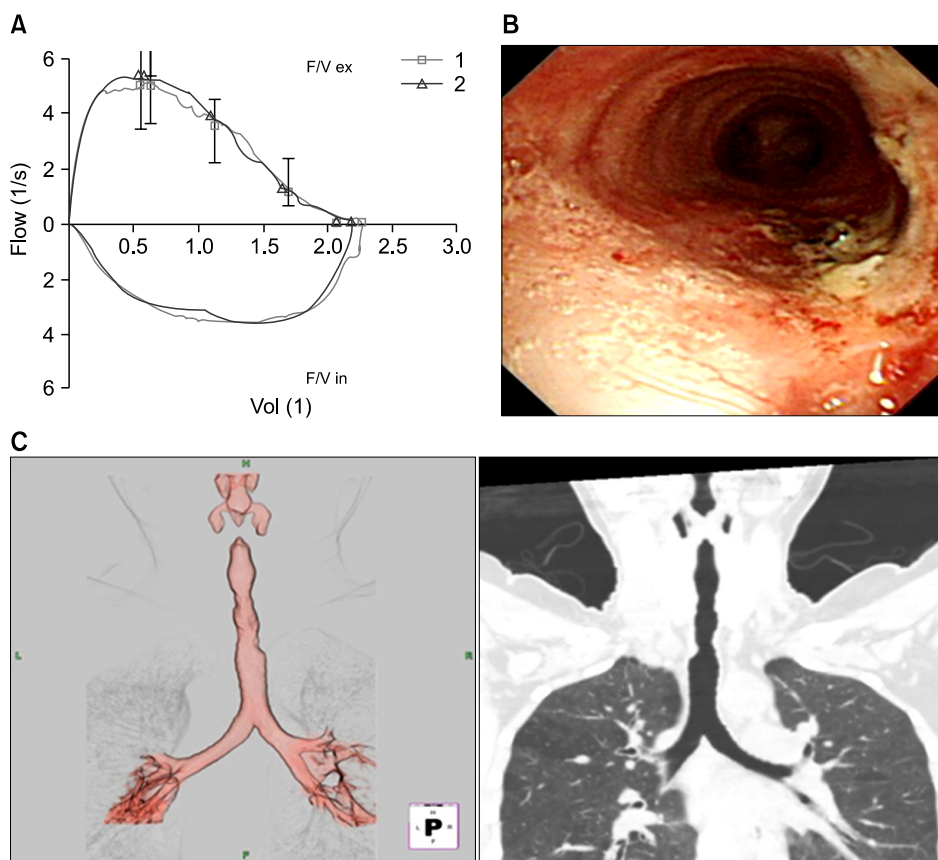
Two-month post-operative findings. (A) Flow volume curve showed normal pattern. (B) Bronchoscopy revealed the improvement of tracheal stenosis. (C) Chest computed tomography showed the tracheal obstruction was completely removed.
